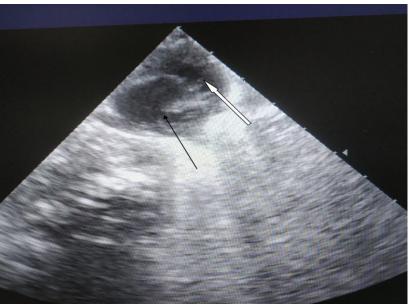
Echocardiogram showing atrial septal defect (black arrow) and ventricular septal defect (white arrow).
